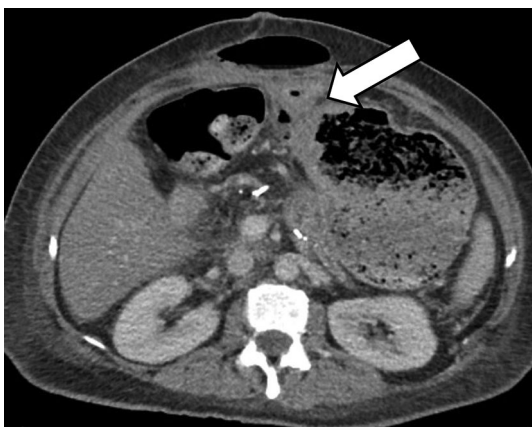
Anastomotic leak after Whipple resection. Axial contrast-enhanced CT in a patient with gastrojejunostomy anastomotic leak resulting in anterior abdominal wall collection, shows focal wall thickening at the anastomosis, with air-filled tract extending into the anterior abdominal wall (arrow). Note moderate gastric distension with retained residue
